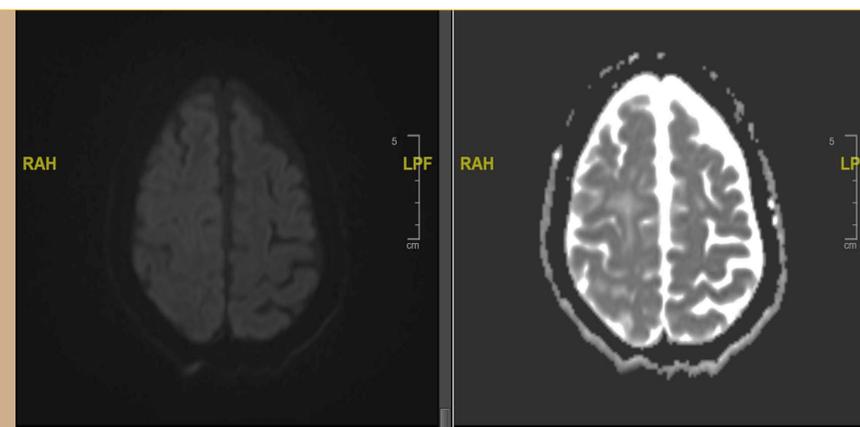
This is the repeat MRI brain done 21 days after the initial MRI brain, after treatment of patient's focal seizures. demonstrated the resolution of the right frontal DWI restriction (on the left) with resolution of ADC (on the right) drop-out.
